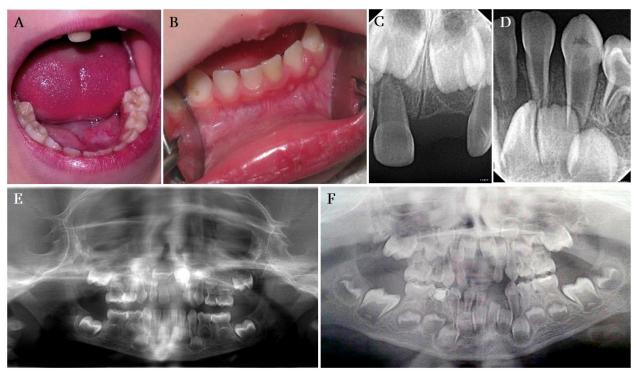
Periapical abscess with sinus: carious teeth (A), sinus in area of 7.1 and 7.2- Change in tooth color (B), A.O. 51 Visiodentogram (C), A.O. 71,81 Visiodentogram (D), Patient A.O. - Orthopantomography (E), Orthopantomography after 1 year and 9 months (F)
